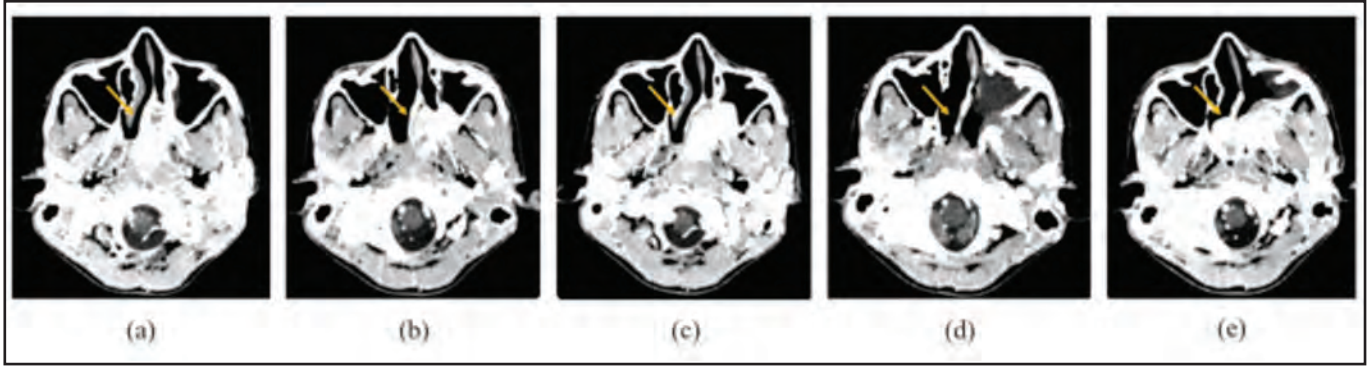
Serial multislice computed tomography (MSCT) before radiotherapy: (a) pre-operative 1 in 2018, (b) pre-embolisation pre-operative 2 in 2019, (c) post-operative 2 in 2019, (d) post-operative 3 in 2020, (e) post-operative 4 in 2021. Orange arrows indicate the tumour
